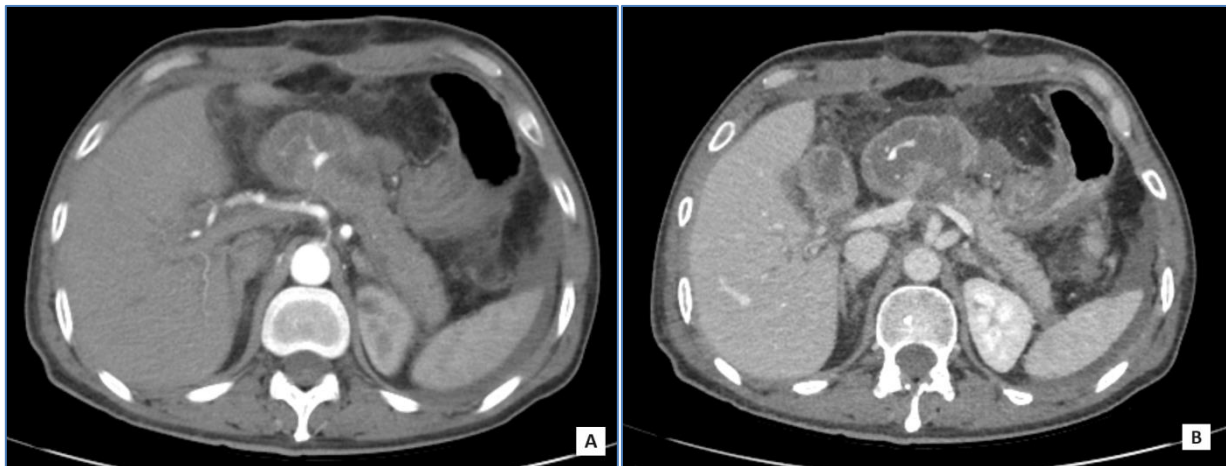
Abdominal CT angiography showing an addition image next to the pancreatico-jejunal anastomosis area, probably related to a pseudoaneurysm of the dorsal pancreatic artery (A), and late intrajejunal extravasation of contrast product (B)
